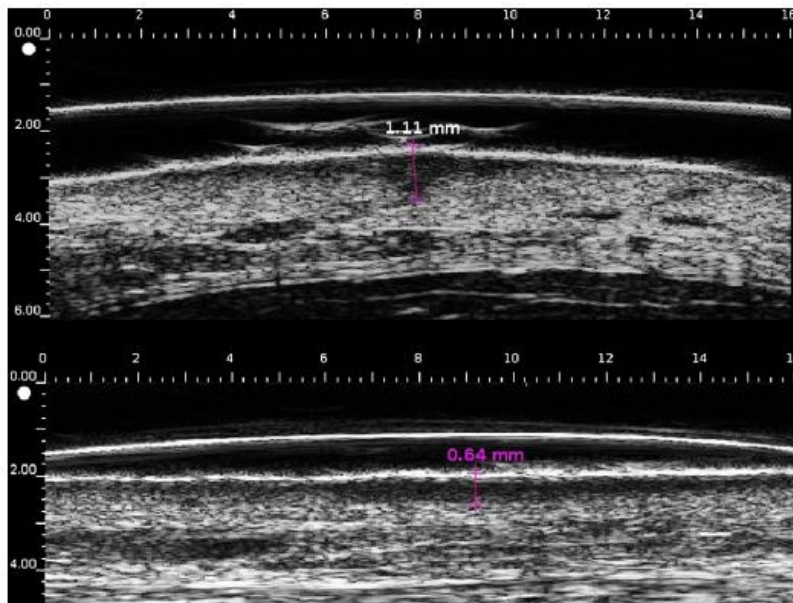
High frequency ultrasound imaging of two melanoma lesions [114]. Lesions were generally hypoechoic and well demarcated from the dermis.
